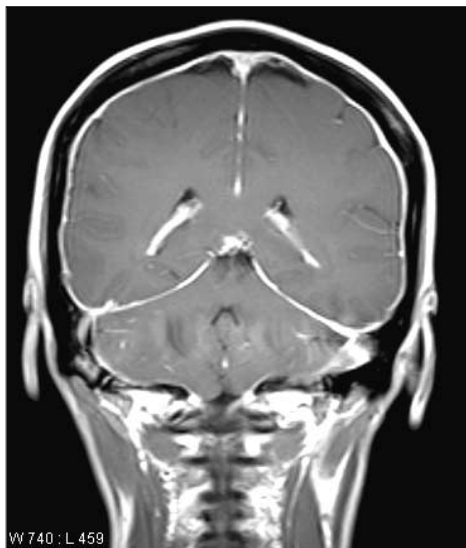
Patient 4. Coronal T1-weighted gadolinium-enhanced MRI shows diffuse pachymeningeal enhancement
